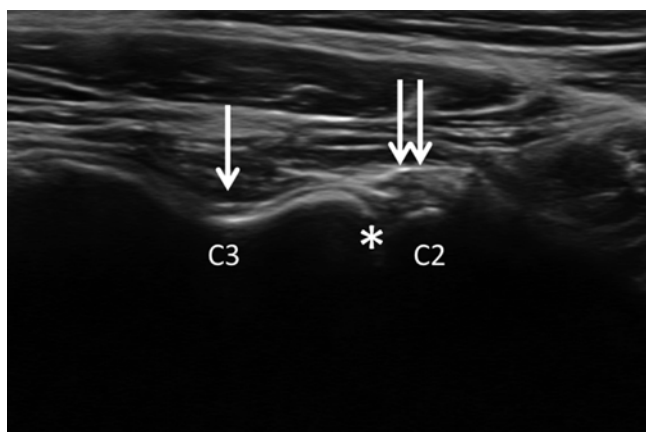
Ultrasound image of the facet joint C2–3 in the longitudinal plane. * facet joint cleft of the joint C2–3. *Single arrow* medial branch C3. *Double arrow* third occipital nerve, which runs over the joint cleft of C2–3. (With permission of Dr. Andreas Siegenthaler)
